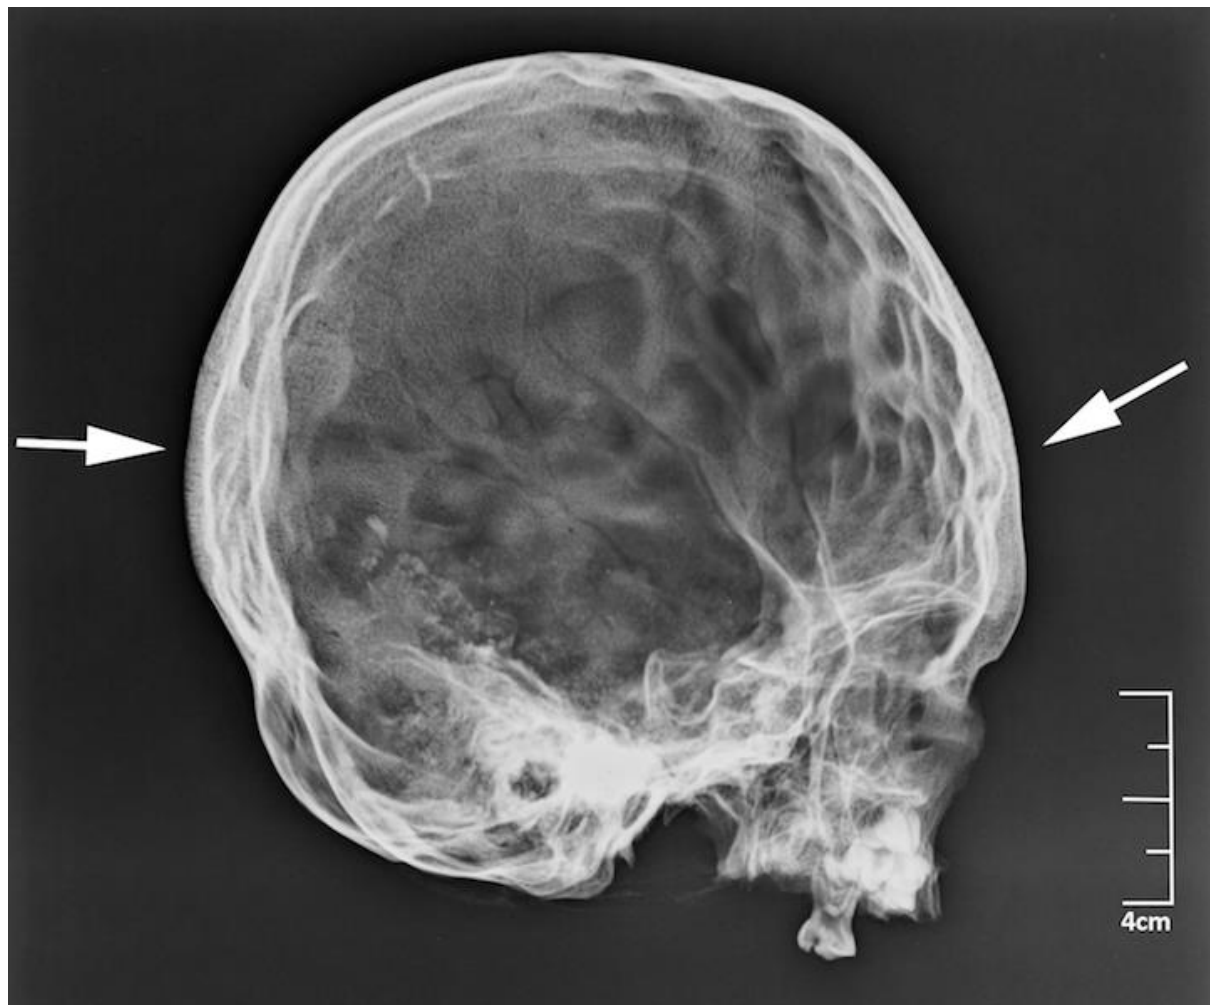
Lateral view radiograph of the cranium of Az122 T9. The image shows “hair-on-end” hypertrophy (accentuated vertical trabeculae between the inner and outer tables) in the occipital and frontal bones (arrows). The trabeculae (diplöe) is visibly expanded in the occipital. The endocranium also shows several depressions and thinning of the tables, likely relating to premature suture fusion and intracranial pressure.
